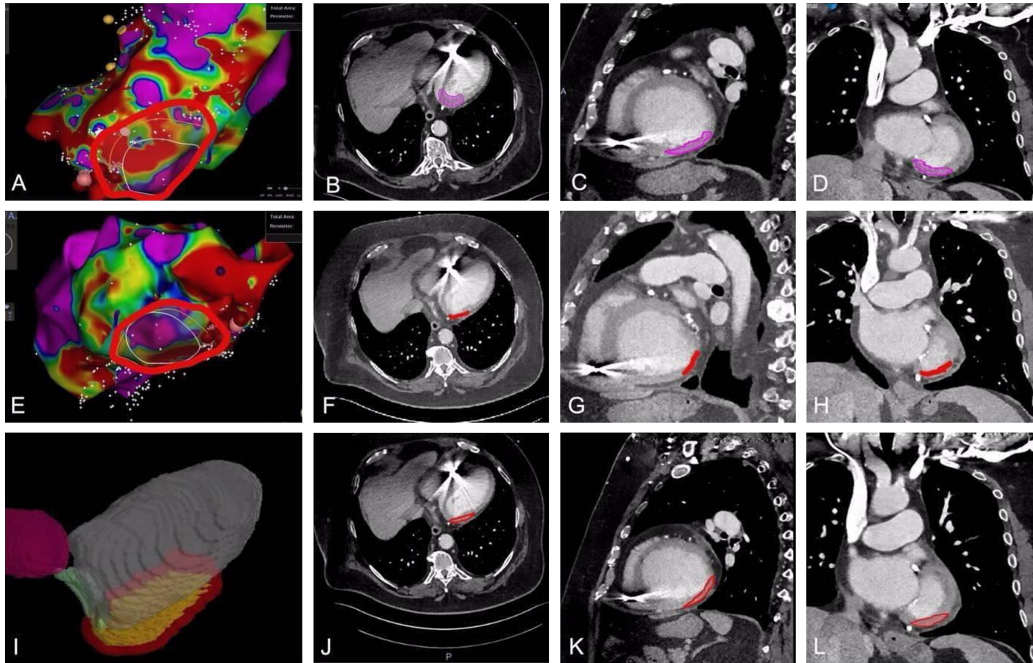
Case 3. (A, E) Electroanatomical mapping (EAM) data with the ventricular tachycardia target region (red) in inferior and posterior-anterior views from CARTO 3 system. (B-D) Axial, sagittal and coronal views of the cardiac computed tomography (CT) with manually transferred clinical target volume (CTV, magenta). (F-H) Axial, sagittal and coronal views of the cardiac CT with the 2D-3D registered CTV (red). (I) 3D view of the registered CTV. (J-L) Axial, sagittal and coronal views of the cardiac CT with the final CTV (red).
